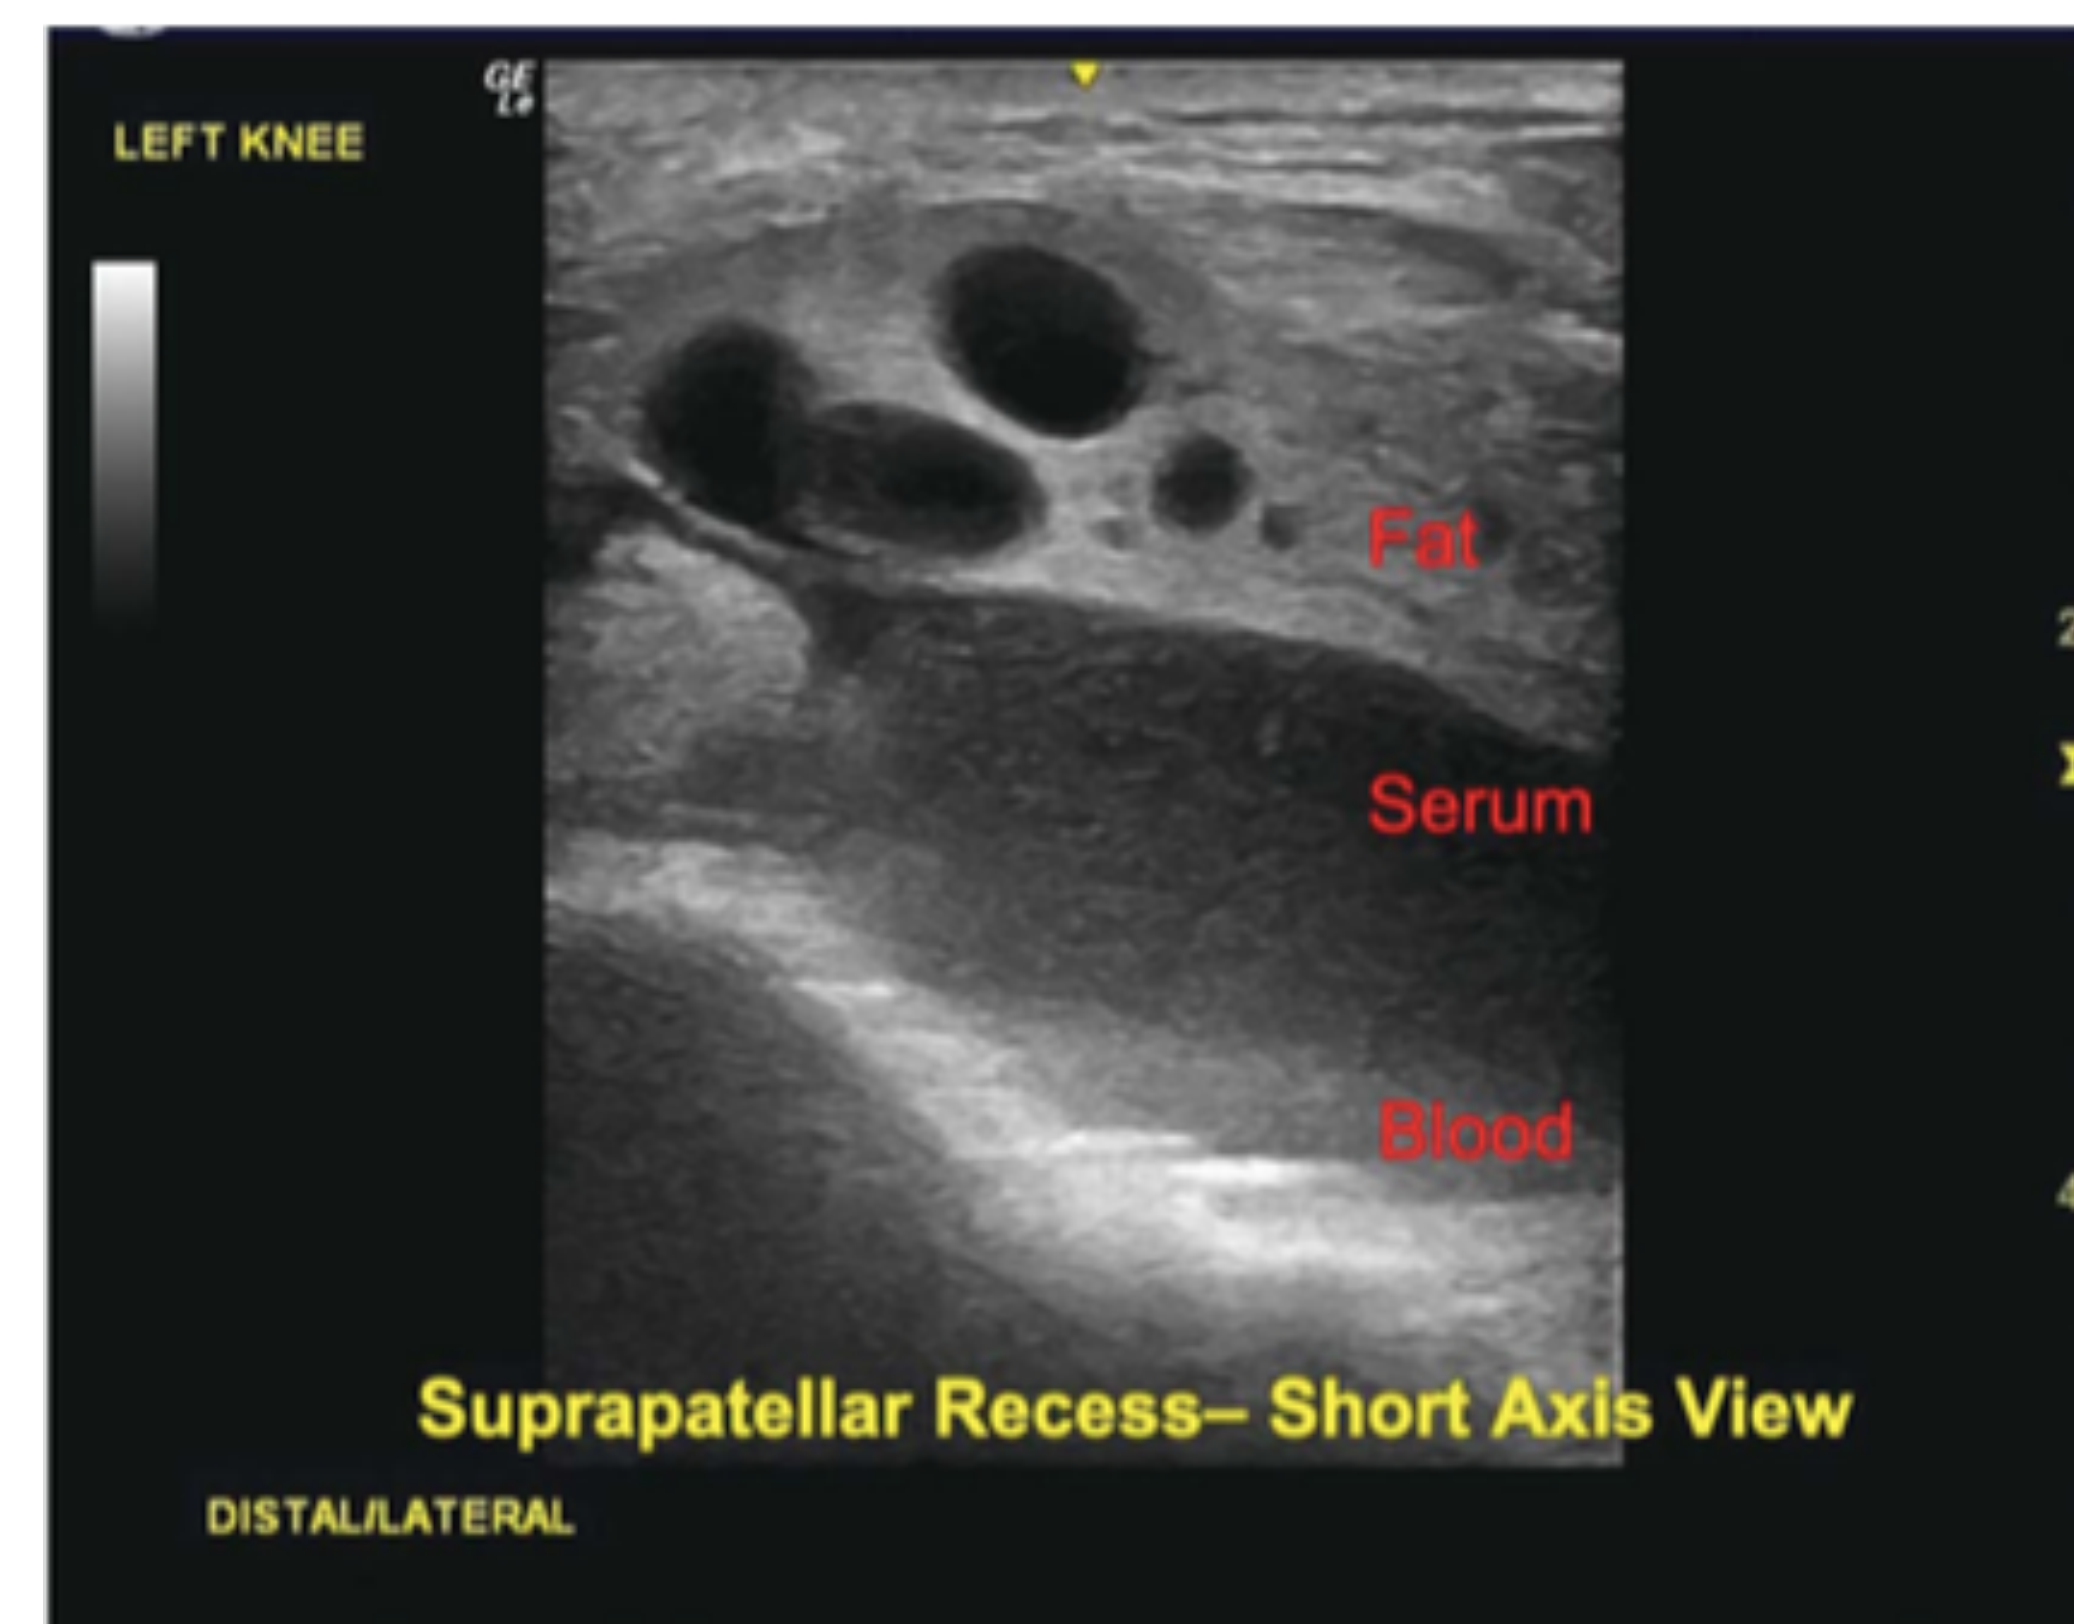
Ultrasound image of the left suprapatellar recess in an anatomical transverse view showing three distinct layers, from superficial to deep, of fat, plasma, and red blood cells, as indicated on the image.
